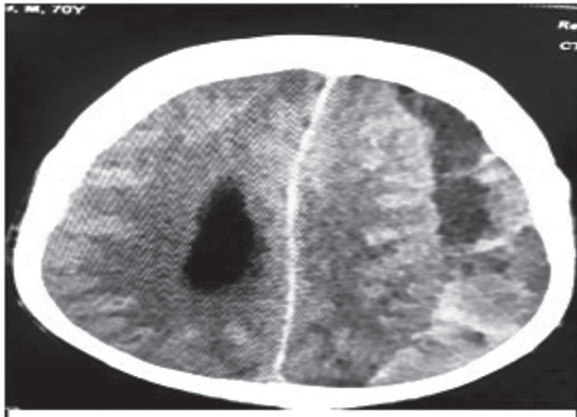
CT scan of brain. Left sided large acute sub-dural hemorrhage (SDH).
